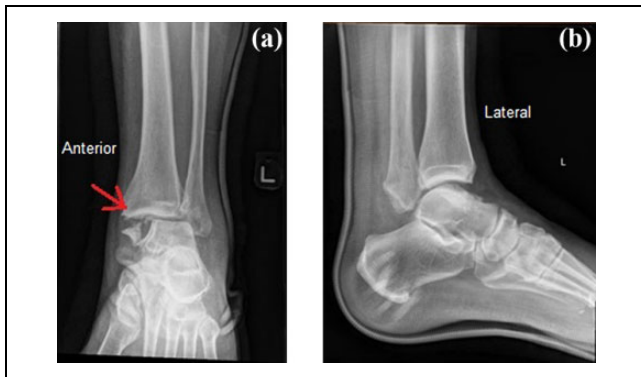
(a) Preoperative anteroposterior radiograph of the left ankle. (b) Preoperative lateral radiograph of the left ankle.
